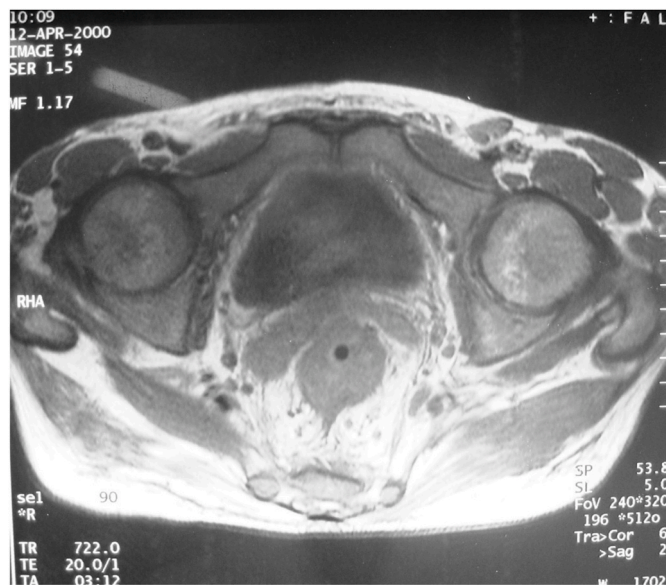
Magnetic resonance imaging of the perineum: presence of multiple non-communicating fistulous paths with the rectum.
